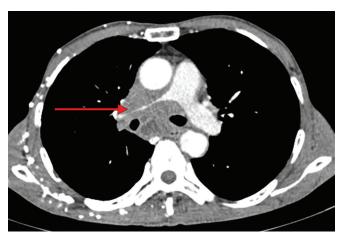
Axial contrast-enhanced CT of the chest showing mass encasing and attenuating the right pulmonary artery (arrow)
